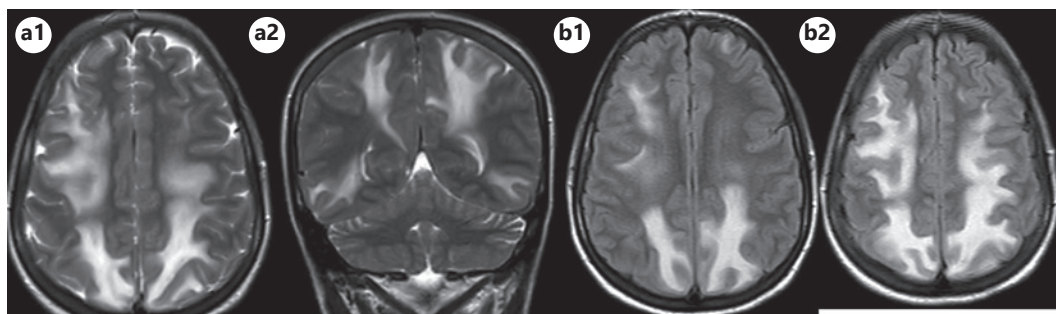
MRI shows bilateral subcortical white matter lesions in parietal, occipital, and temporal lobes. Hyperintense on T2-weighted (a1–2). Hyperintense on FLAIR (b1–2). MRI, magnetic resonance imaging.
